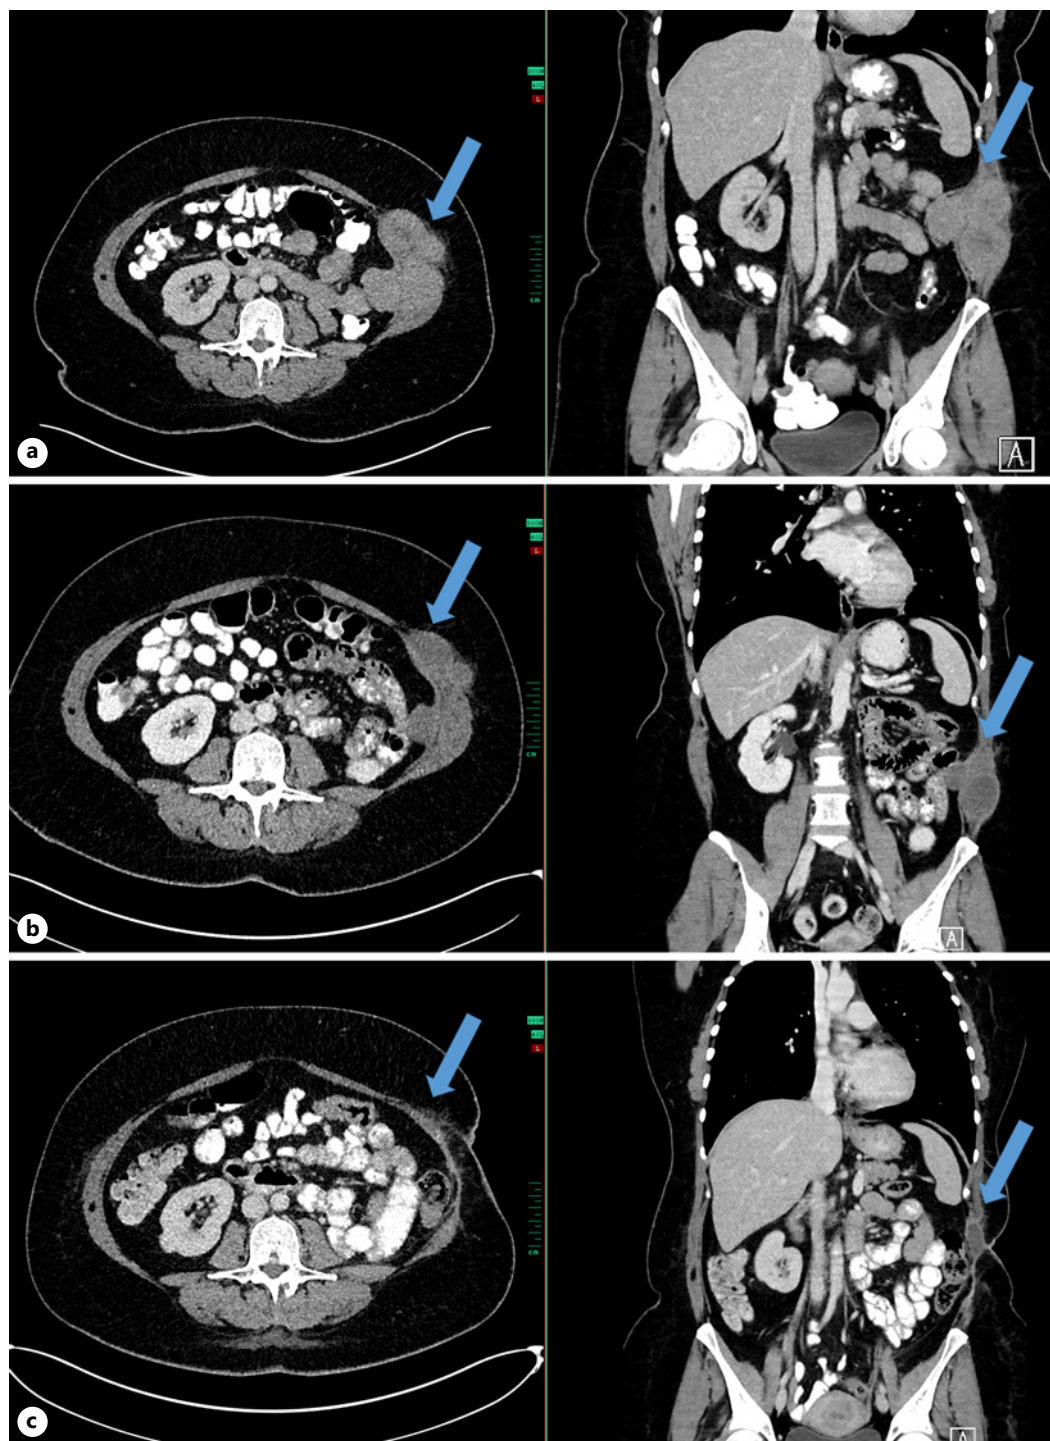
Transversal and coronal planes of CT scans upon initial diagnosis of local recurrence (a – top), preoperatively after 3 months of treatment described as partial remission (b – middle), and showing a post-operative seroma (c – bottom).
